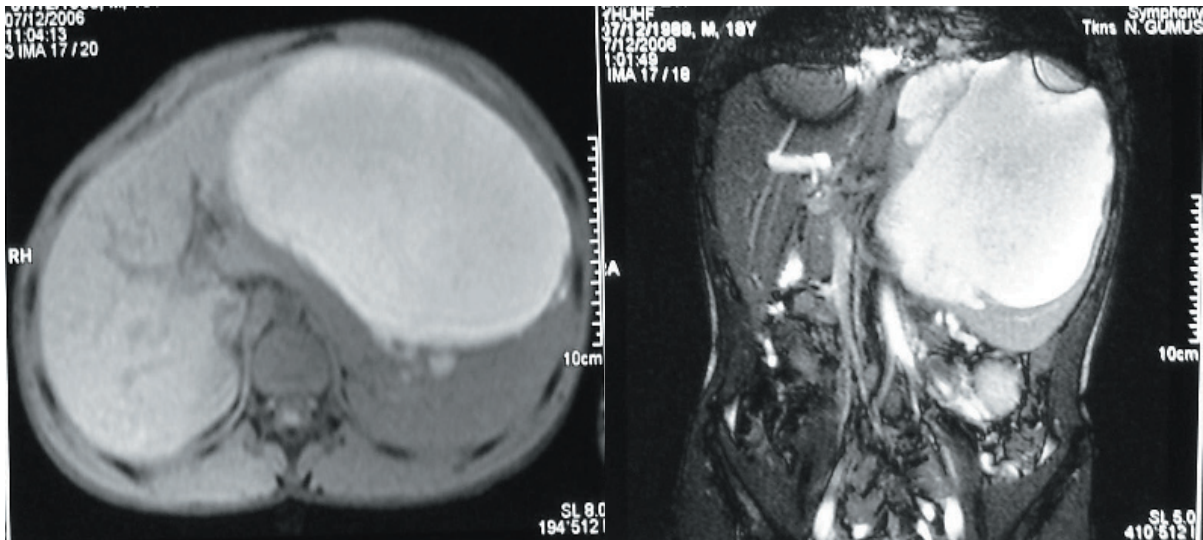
a, b: Non-contrast enhanced T1W axial [a] and T2 W coronal MRI [b] examinations revealed hyperintense large spleen cyst.
